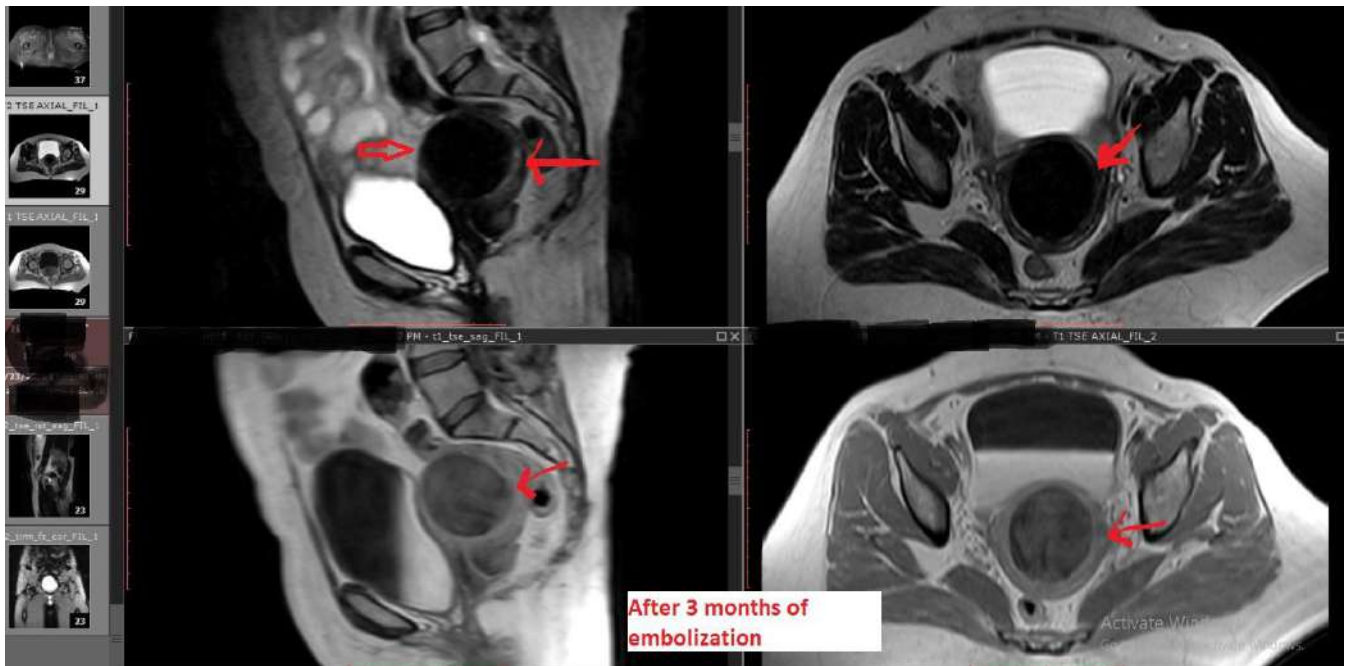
b: MR images 3 months after embolization shows complete necrosis of the fibroid and is replaced by fluid filled cavity.
